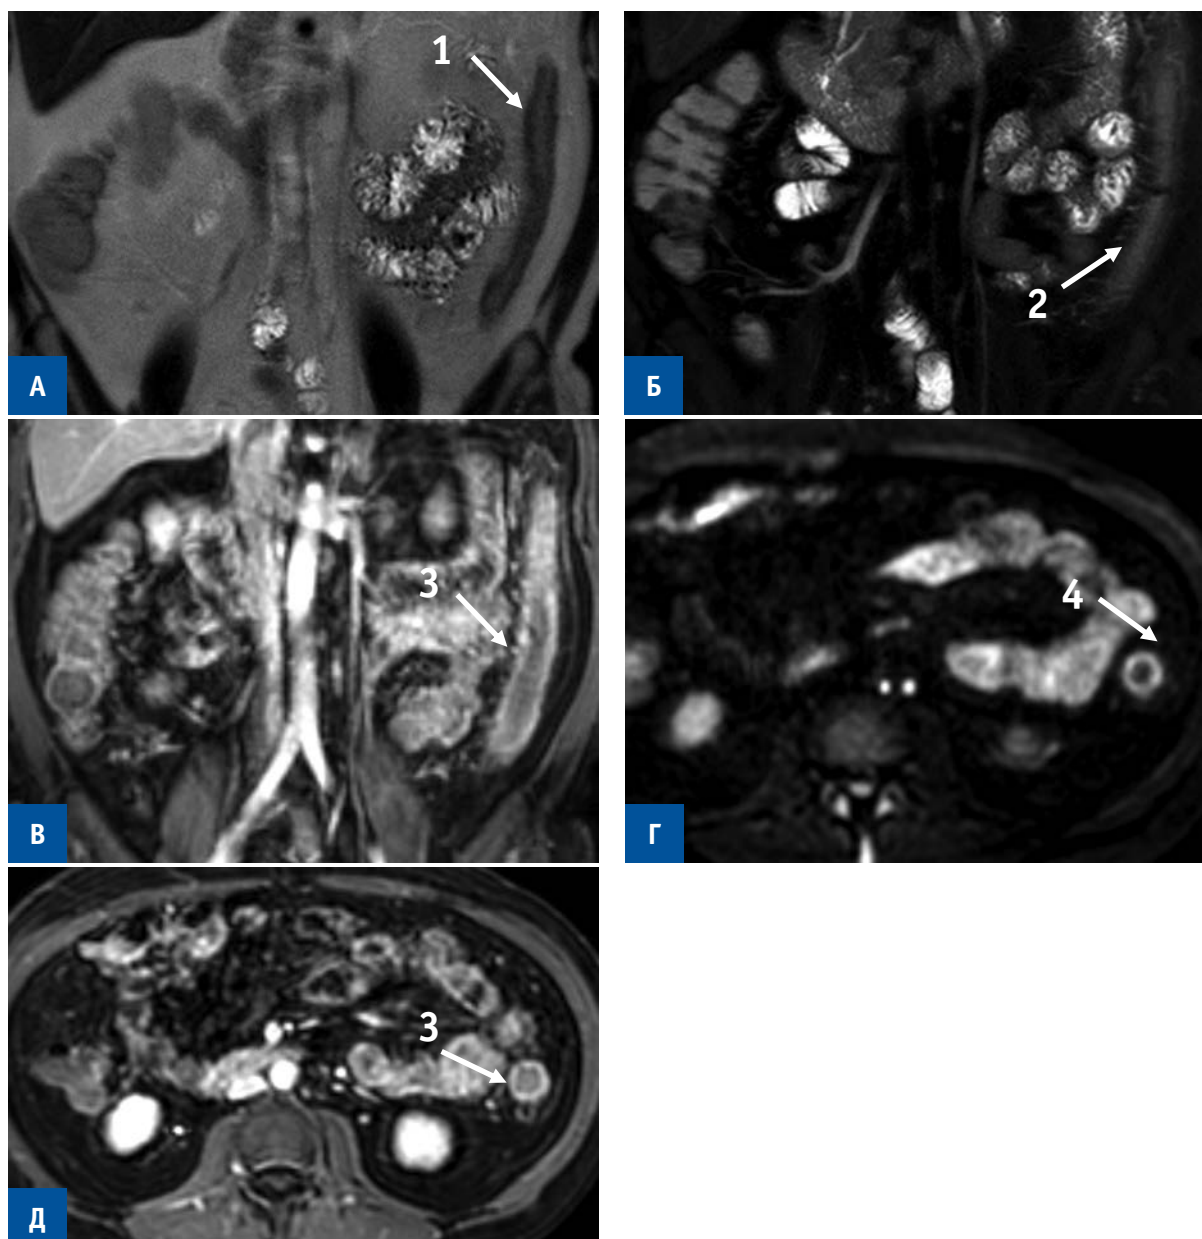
MRE. Crohn's disease in the form of ileitis. A — T2-weighted image, cor; Б — T2-weighted image with fat suppression, cor; В — T1-weighted image with contrast enhancement, cor; Г — diffusion-weighted image, ax; Д — T1-weighted image with contrast enhancement, ax. 1 — thickening of the intestinal wall, 2 — hypervascularization of the adjacent fiber, 3 — increased accumulation of the contrast agent, 4 — restriction of diffusion from the intestinal wall.
